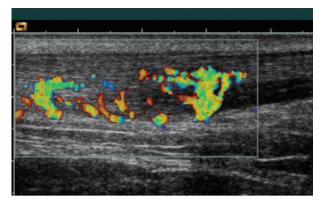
Neovascularization. Gray-scale ultrasonography and color doppler examination (a longitudinal view) of an Achilles tendon with tendinosis located at the 2-6 cm level in the tendon. The coloration represents a neovascularization, located outside and inside the ventral part of the area with structural tendon changes.
